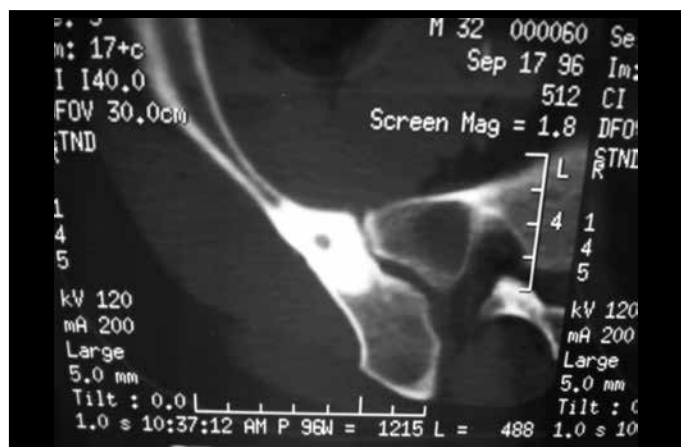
Case 1: computed tomography.
